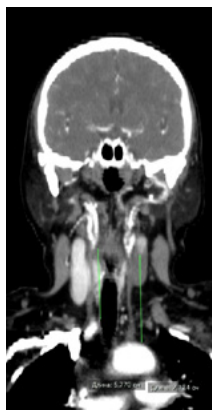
CT Angiography of the head and neck of patient N, coronary projection: long stretches of obliteration of both common carotid arteries
